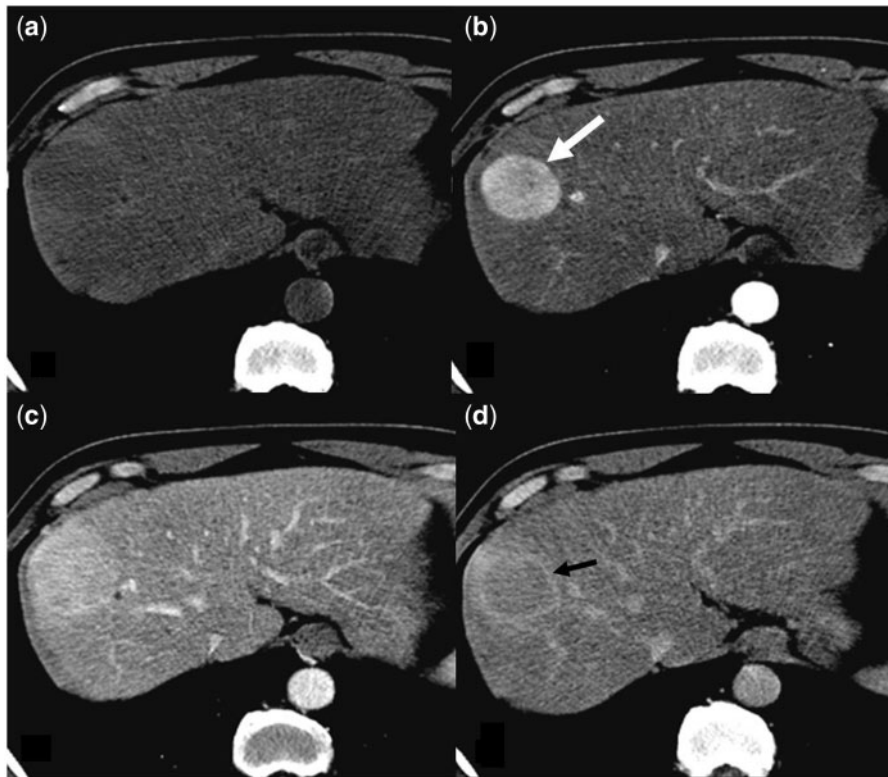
HCC in a 58-year-old man with chronic hepatitis B. Unenhanced (a), arterial phase (b), portal venous phase (c) and delayed phase (d) CT images showing a rounded HCC (white arrow) that enhances in arterial phase and washes out in portal venous and delayed phases. A thin enhancing pseudocapsule (black arrow head) is best demonstrated in the delayed phase.
